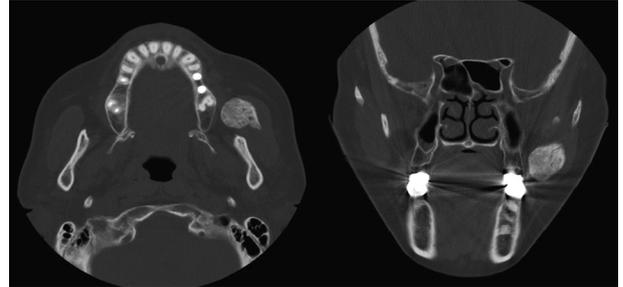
CT image showing a round pedunculated hard tissue mass approximately 3 cm in diameter in masseteric space (Case II).
